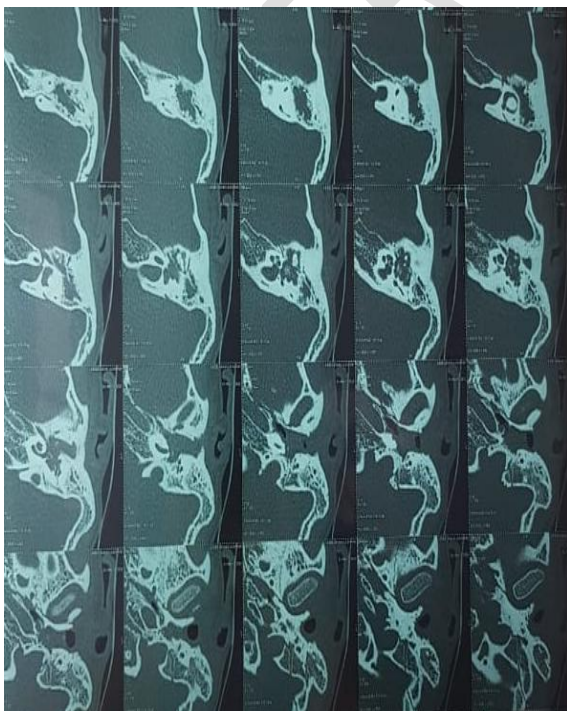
CT of the left petrous bone showing filling of the tympanic cavity, partial lysis of the malleus and incus, bare appearance of the facial nerve in its tympanic portion, lysis of the tympani and antrii tegmen with blunt appearance of the wall of the cell filling of mastoid cells.
